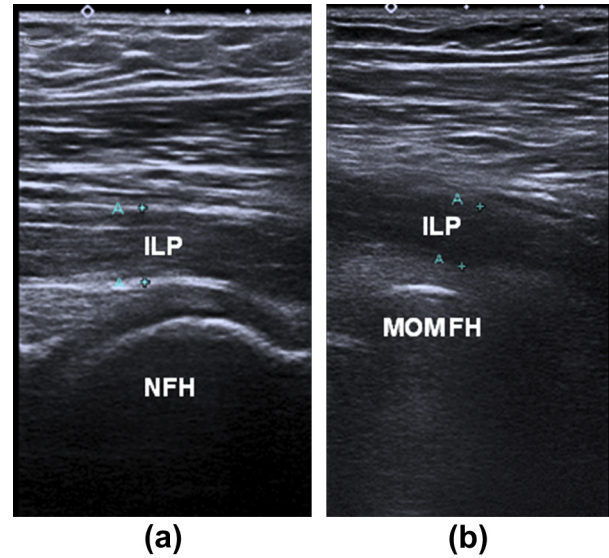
Ultrasound images of the iliopsoas tendon (cranial aspect to left of the images). Anterior longitudinal images showing (a) the iliopsoas tendon running anterior to the native femoral head and (b) tendinosis of the iliopsoas tendon with hypoechogenicity. ILP, iliopsoas tendon; NFH, native femoral head; MOM FH, metal-on-metal femoral head.
